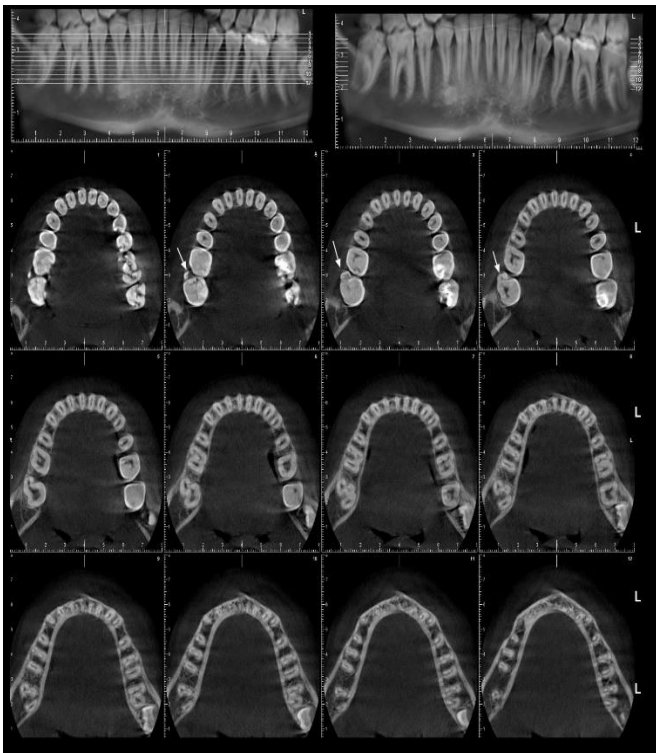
Cone Beam Computed Tomography images showing complete separation of the pulp chambers of second mandibular molar and the supernumerary teeth.
